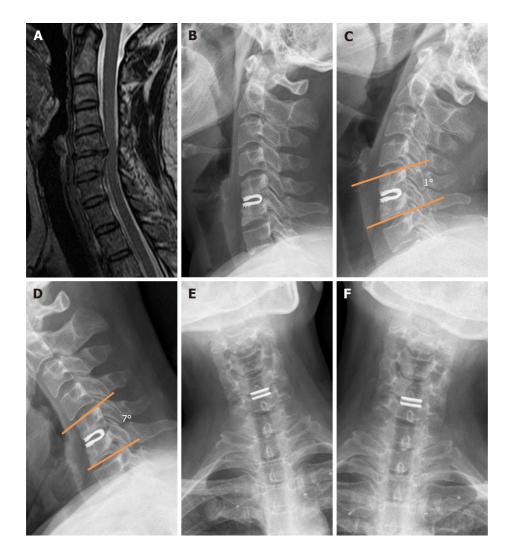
A 50-year-old woman suffering from C5-6 degenerative disc disease. A: Pre-operative magnetic resonance imaging demonstrated C5-6 disc herniation; B: At the 5-year follow-up, the neutral lateral radiograph showed a normal position of dynamic cervical implant; C and D: Dynamic radiographs showing that the functional spinal unit range of motion maintained; E and F: The lateral bending at the operated level was limited.
